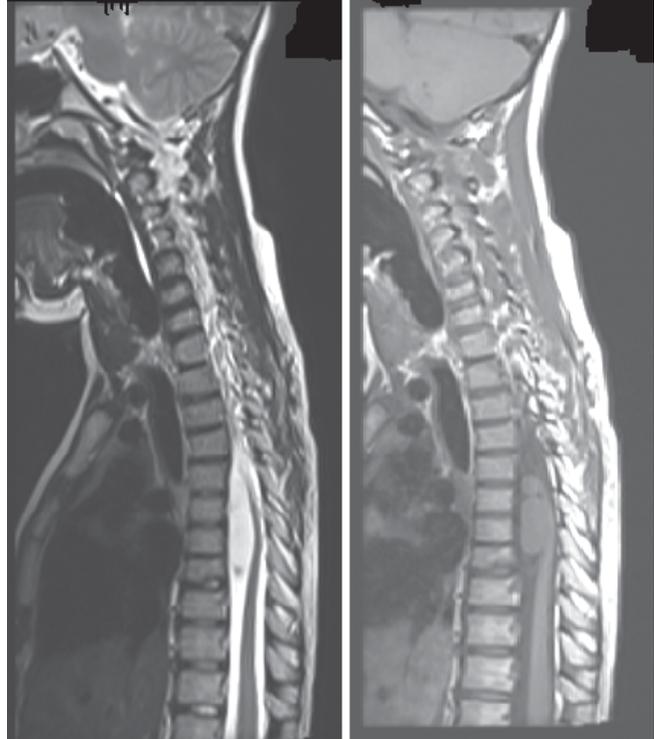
MRI showing sagittal section of the cervico-dorsal spine with the Neurenteric cysts at T5-8 level, T1 (cysts are isointense) and T2 (cysts are hyperintense) weighted images
